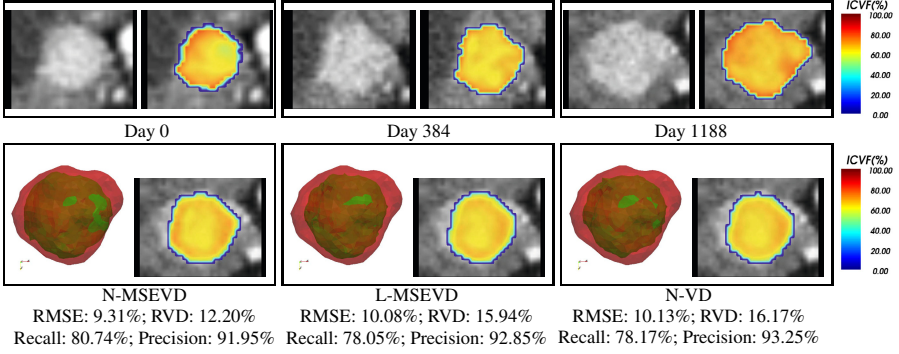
Clinical data. Top: CT and ICVF at three time points. Bottom: prediction at the third time point, with the measured (red) and predicted (green) tumors superimposed.
